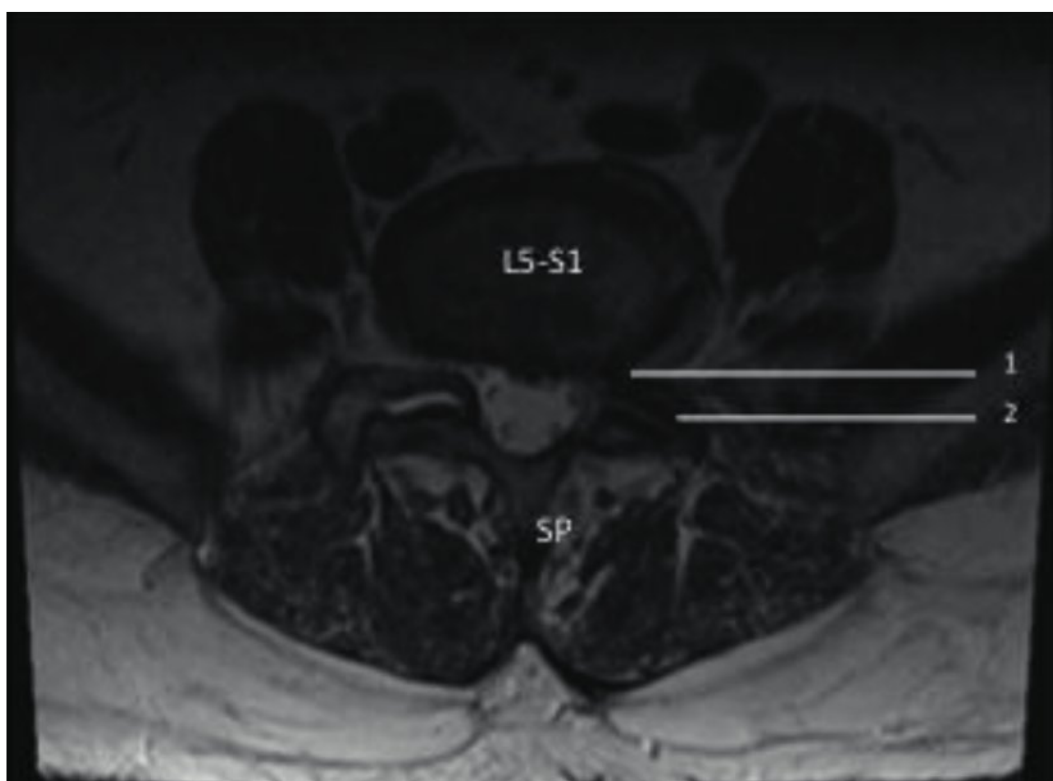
Magnetic resonance imaging axial cut L5–S1 disk. 1, left foraminal stenosis; 2, facet joint arthropathy; SP, spinous process.
